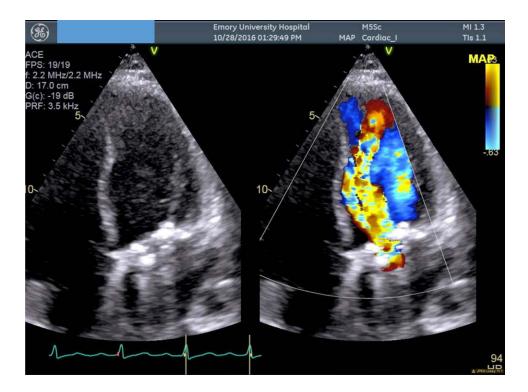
TTE at 24 wk reveals undersized MMV causing "functional" mitral stenosis with significant turbulent flow seen on Doppler. Turbulent flow is represented by the large jet that extends from the MMV into the left ventricle and aliasing seen on color flow Doppler. MMV indicates mechanical mitral valve; TTE, transthoracic echocardiography.
